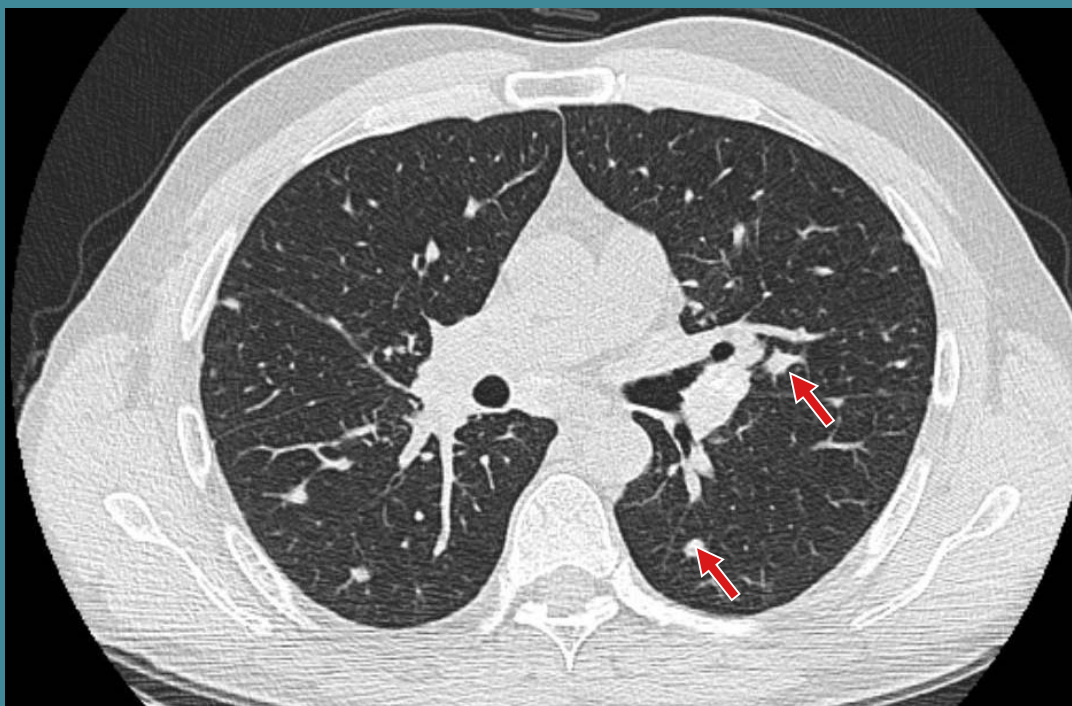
Chest CT showing bilateral hilar enlargement through the presence of multiple hilar lymphadenopathies and multiple pulmonary nodules, of variable size, round-oval, disseminated in both pulmonary fields
